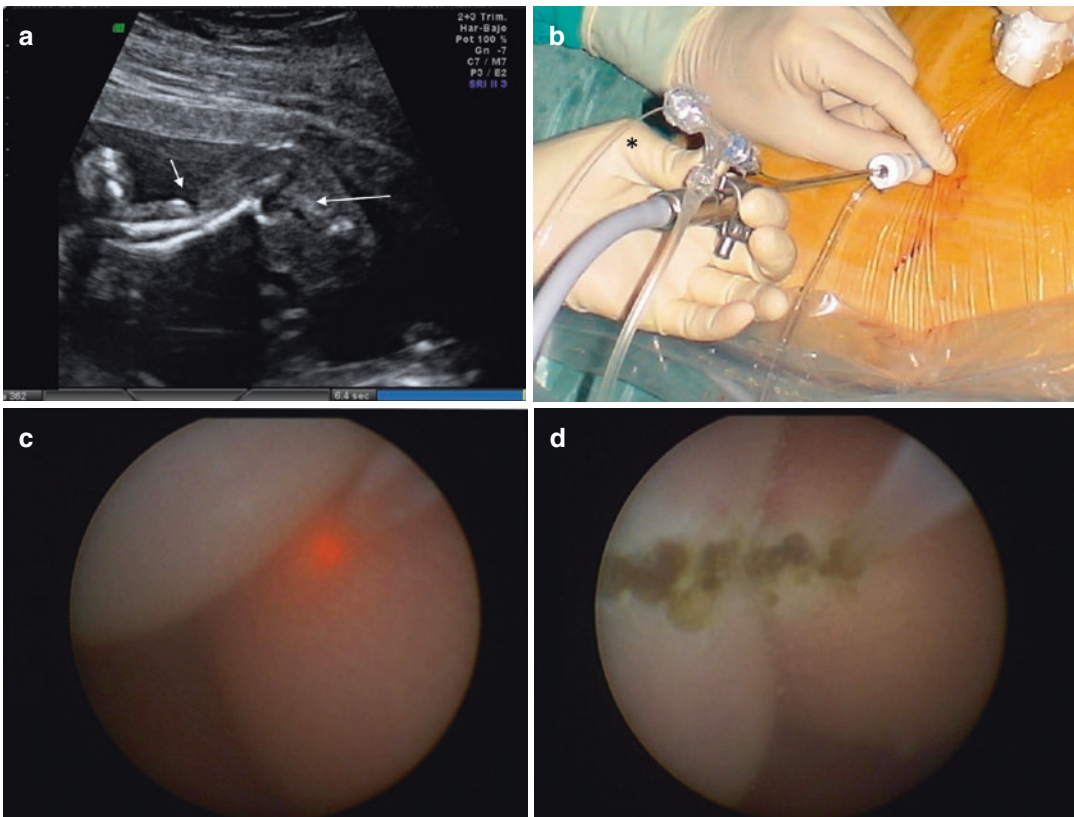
Amniotic band syndrome. (a) Prenatal ultrasounds can detect constrictive amniotic band in a fetal extremity. (b) Percutaneous fetoscopy with laser fiber (asterisk) through the working channel. (c) Constrictive amniotic band in a fetal leg with significant distal edema. (d) Interstitial laser for perpendicular cutting of the constrictive fibrous tissue
